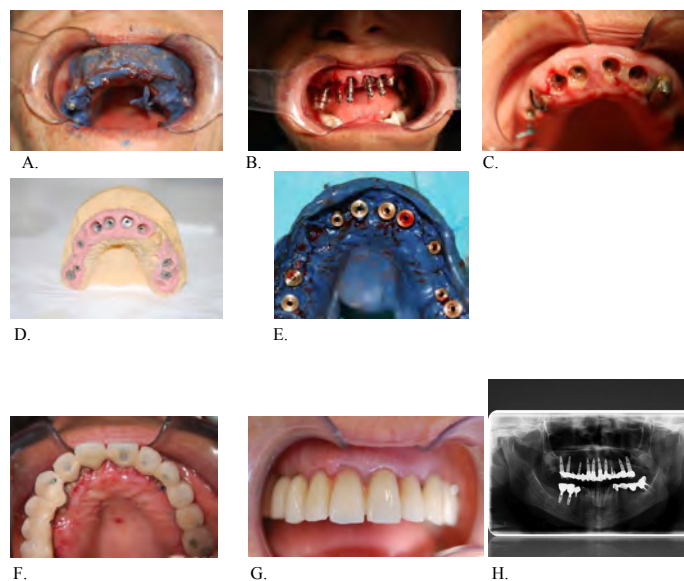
Screw-Retained Technique.* A): Intrasurgery impression; B): Transfer Impression; C): Multi-unit abutments and transmucosal tissue after 48 hours; D): Plaster model; E): Intrasurgery impression; F): Occlusal view; G): Front view; H): Final x-ray.
